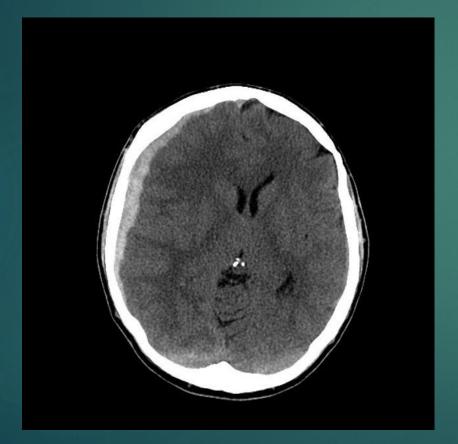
Revealing CT scan 2 weeks after initial presentation
